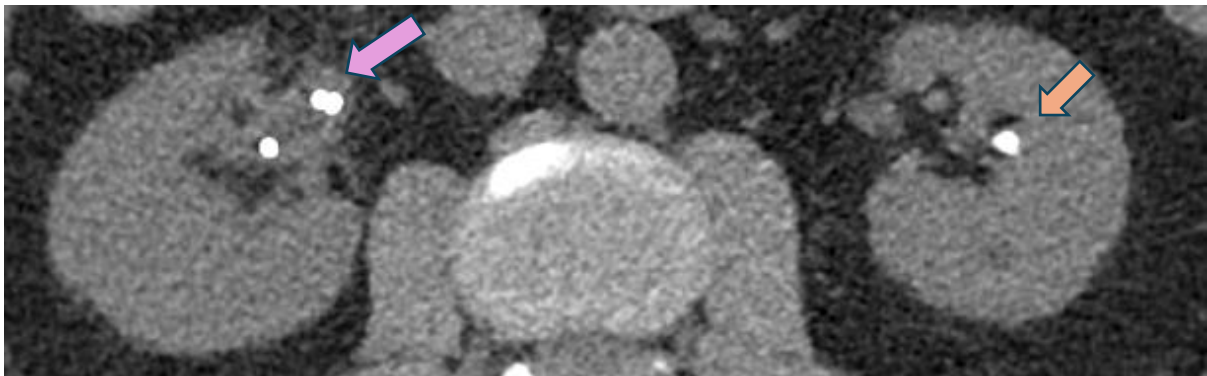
The CT of March 2024 shows a 4mm pericatheter stone that is indicated with a purple arrow, and a 7mm kidney stone that is indicated with an orange arrow.
